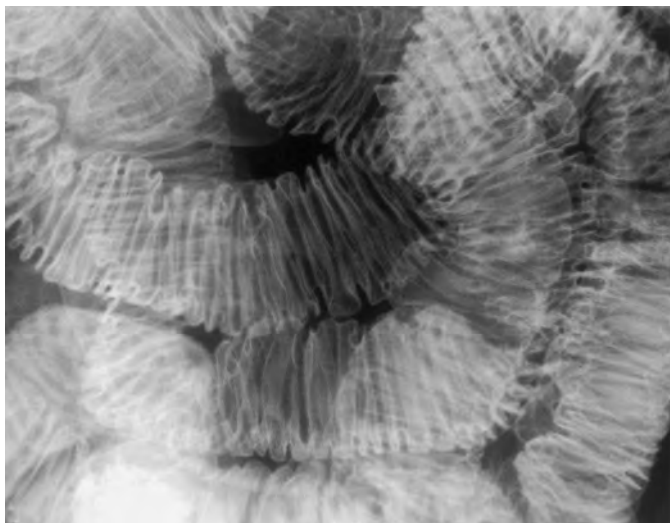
Lymphangiectasia. This spot radiograph of jejunum from enteroclysis shows smooth, mildly thickened, slightly undulating folds.
